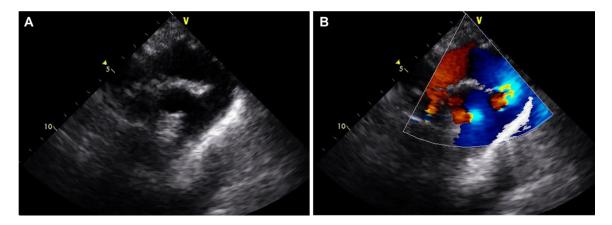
Transthoracic echocardiography. (A) Double aortic arch is shown on suprasternal notch view. (B) On color Doppler echocardiography, the patency of both left and right arches is demonstrated.
